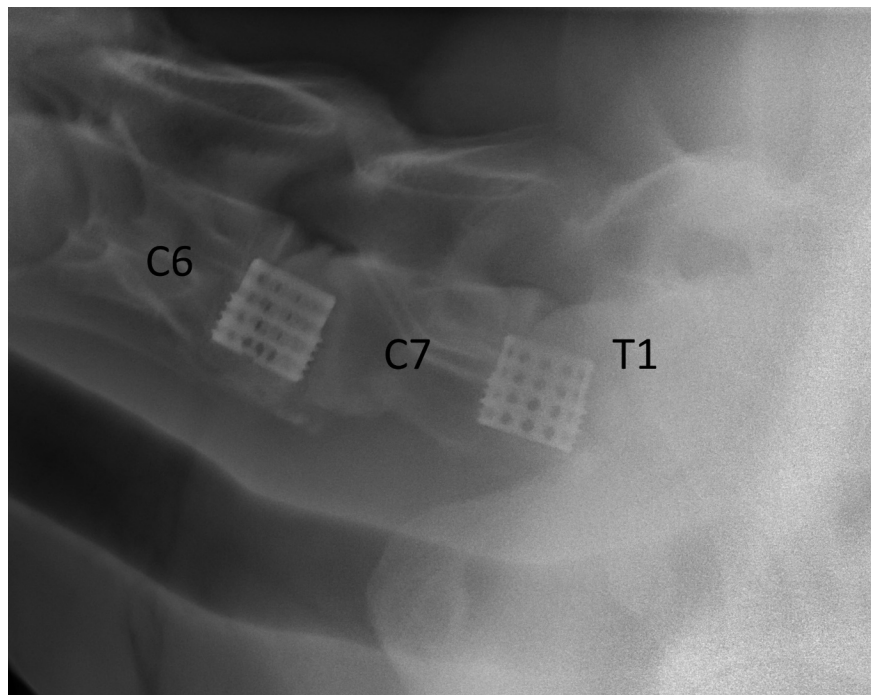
Radiograph obtained 1-year after ventral interbody fusion surgery for cervical vertebral stenotic myelopathy. Partially threaded titanium Kerf-Cut Cylinders packed with cancellous bone graft have been placed at C6-C7 and C7-T1.
